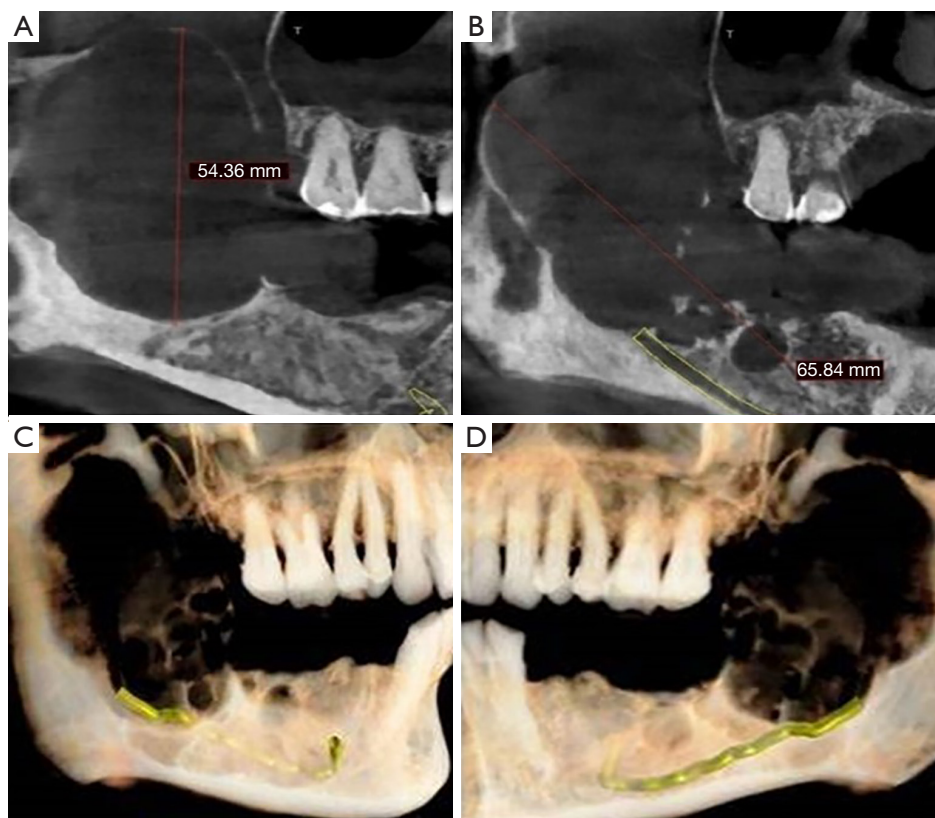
Radiological (digital panoramic and cone beam computed tomography images). (A,B) An ill-defined, multilocular radiolucency with interrupted cortication is seen in the body and ramus of right mandible, involving alveolar crest, ramus, sigmoid notch of the mandible and inferior border of the mandible. Breach of cortical outline of inferior alveolar nerve canal noted in posterior region. The anterior-posterior and mesiodistal extension of the lesion is measured. (C,D) The volume rendering image of CBCT showing the extension of the lesion. CBCT, cone beam computed tomography.
